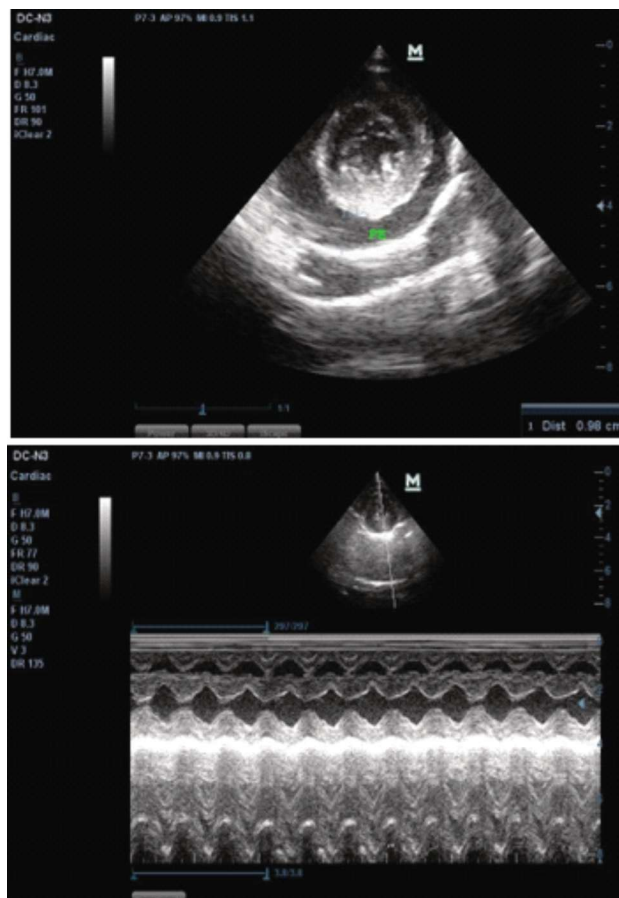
Echocardiography image of a case with severe pericardial effusion resulting in cardiac tamponade.
